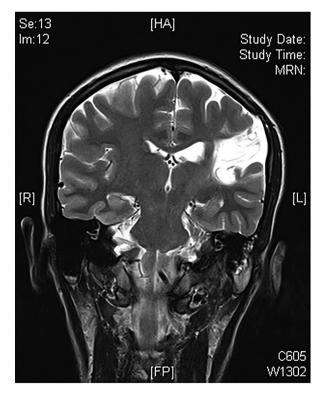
MR scan of brain (T2-weighted) showing typical mature changes following a perinatal middle cerebral artery infarction.
